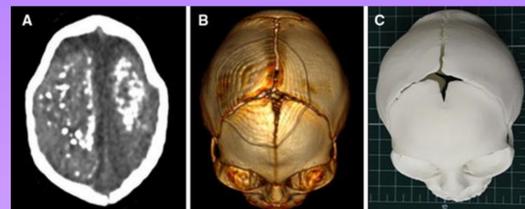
3-D CT reconstruction demonstrates brain calcifications (A) and skull deformities can be shown in the physical modeling of same patient (B, C).⁶
